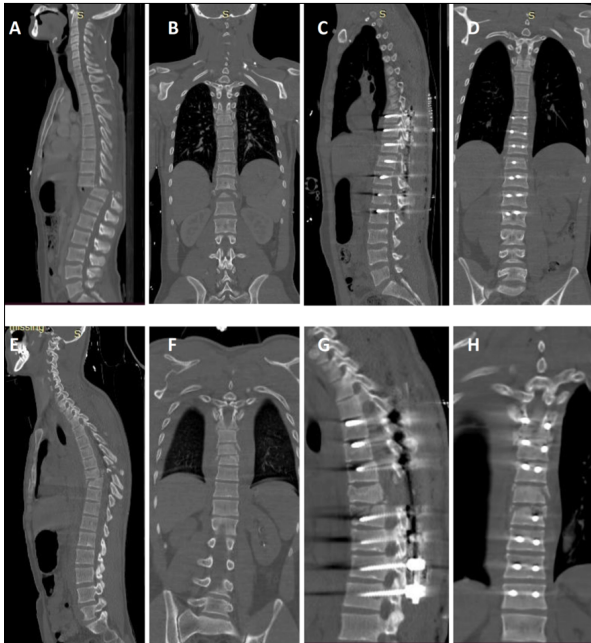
(a) Preoperative sagittal thoracolumbar computed tomography (CT) image of Case 1, (b) Preoperative coronal thoracolumbar CT image of Case 1, (c) Postoperative sagittal thoracolumbar CT image of Case 1, (d) Postoperative coronal thoracolumbar CT image of Case 1, (e) Preoperative sagittal thoracolumbar CT image of Case 2, (f) Preoperative coronal thoracolumbar CT image of Case 2, (g) Postoperative sagittal thoracolumbar CT image of Case 2, (h) Postoperative coronal thoracolumbar CT image of Case 2.
